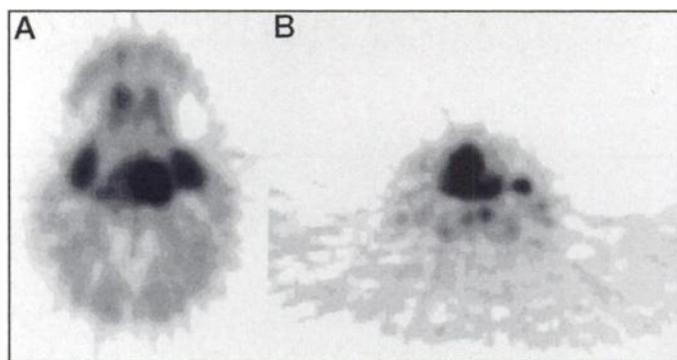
Carbon-11-methionine PET images of 2 patients with advanced (International Union Against Cancer Stage T3N1) laryngeal cancer. (A) Moderately differentiated squamous cell cancer in supraglottic area with neighboring neck metastasis and tumor standardized uptake value (SUV) of 10.2. Sublingual and right submandibular salivary glands are also visible. Patient was alive without disease at 65 mo after diagnosis. (B) Well-differentiated squamous cell cancer in glottic area with tumor SUV of 10.0. Patient died of cancer 9 mo after diagnosis.
